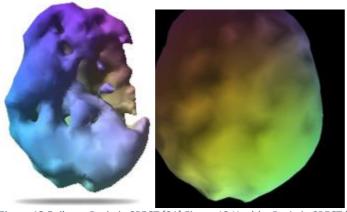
Epilepsy Brain in SPECT [21] Figure 13 Healthy Brain in SPECT [20]
